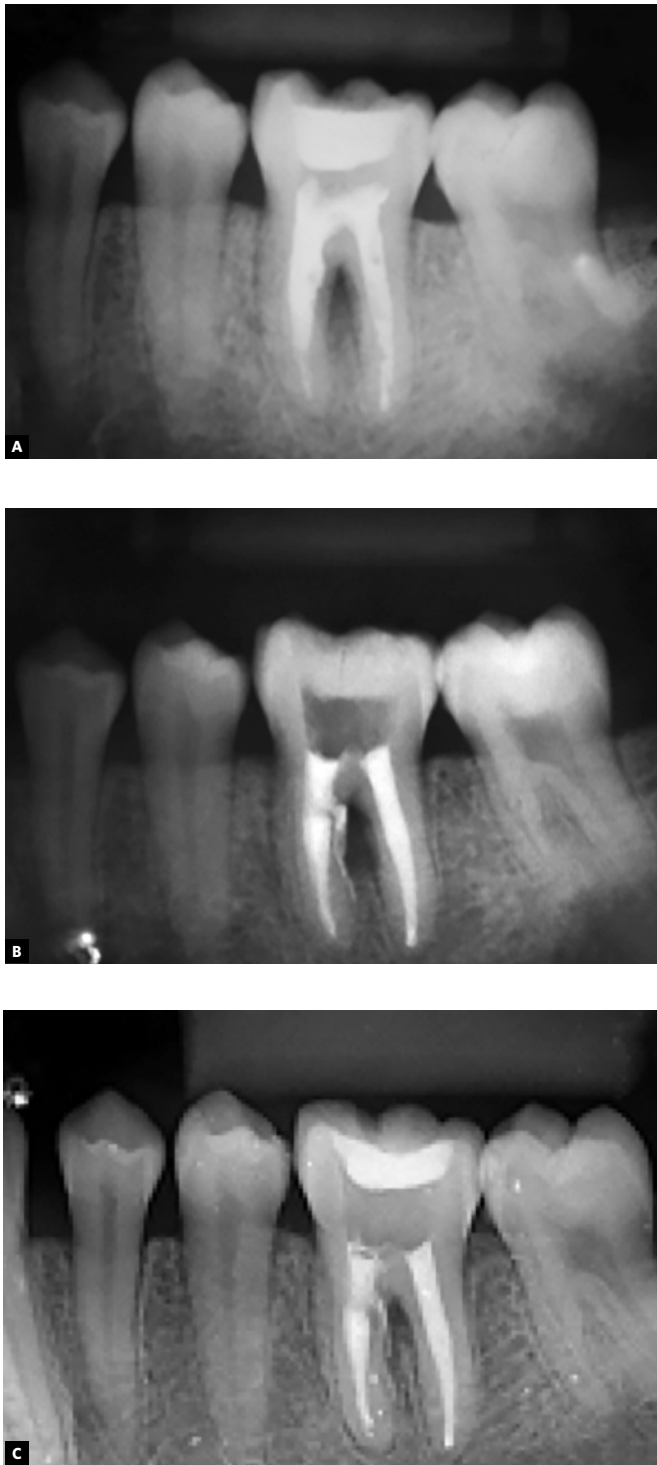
A) Periapical radiograph with calcium hydroxide dressing after 240 days. B) Periapical radiograph showing root canal filling in the 270-day appointment. C) 360-day follow-up.
